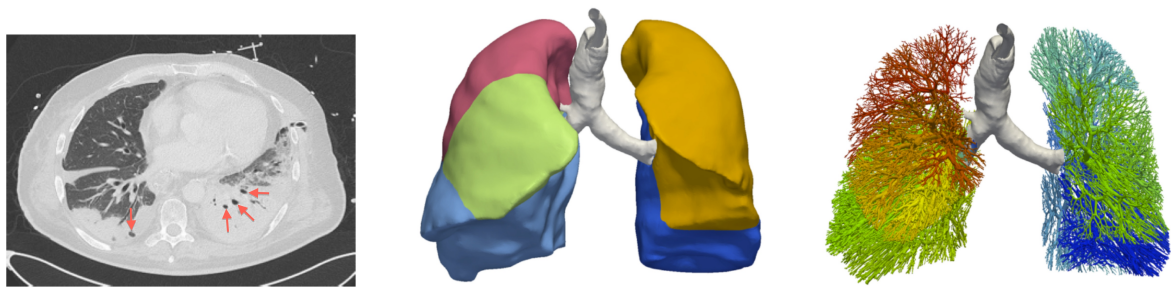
CT scan at EELV (left), segmented lung lobes, larger airways and tracheal cannula (middle), and the fully grown 17-generation airway tree (right). Larger open airways in the atelectatic region are marked by red arrows in the CT scan (left). Taken from [285] with permission.
